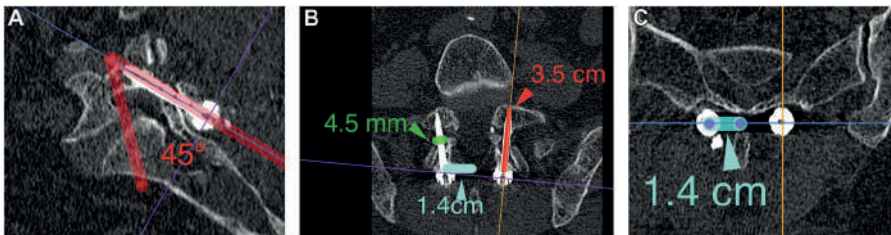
Ideal screw trajectory with 3-dimensional (3D) multiplanar reconstruction using a lumbar computed tomography scan of a patient in whom we performed pars fixation with a percutaneous intralaminar screw. (A) 45° sagittal screw insertion angle. (B) 3.5 cm screw length, 4.5 mm screw diameter. (C) Approximately 1.4 cm lamina lateral screw distance.
